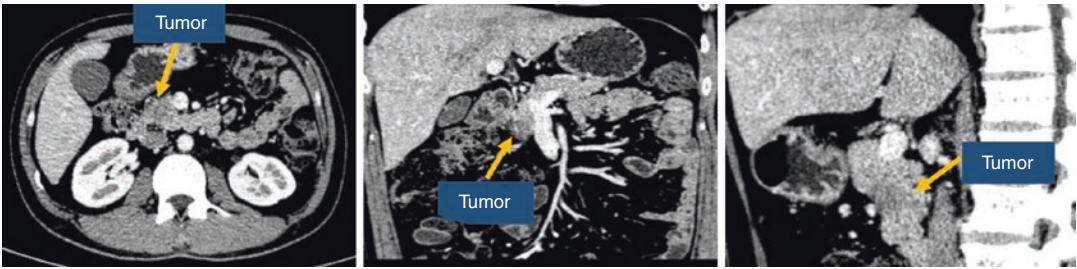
CT image showed a mass in the head of the pancreas
